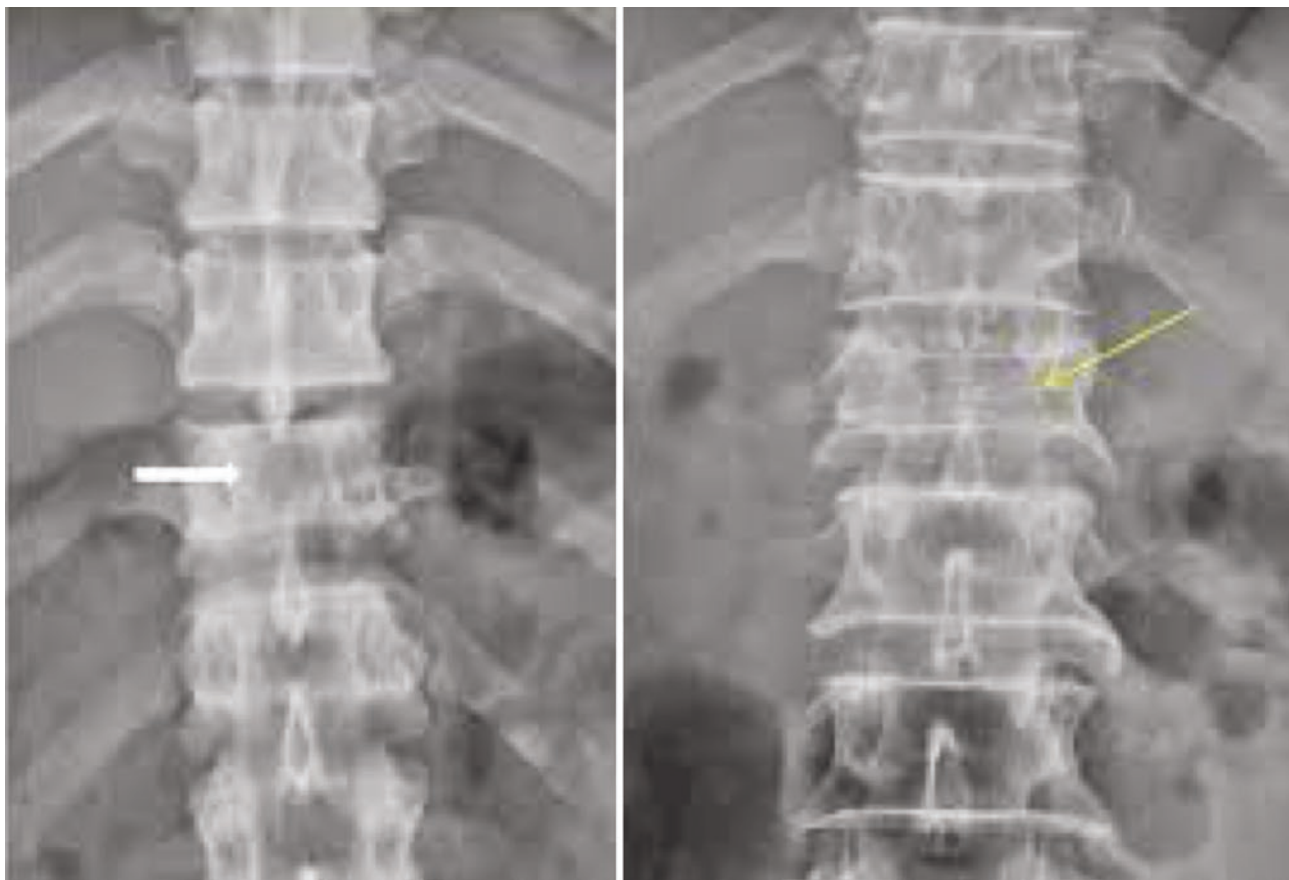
AP radiographs demonstrating interspinous diastasis (arrows) in a distraction thoracolumbar injury. (Copyright © 2016, Rights Managed by Georg Thieme Verlag KG Stuttgart, New York, with permission [55])
